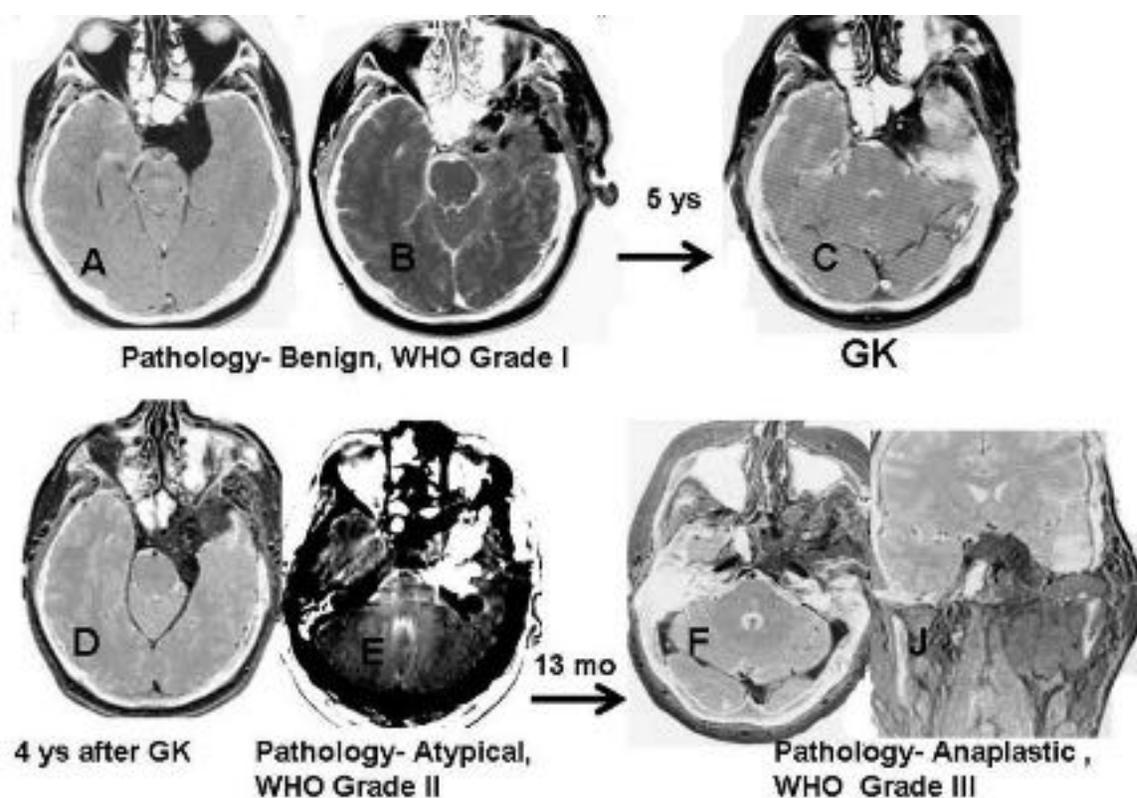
A case of meningioma progression to malignancy with a history of radiation administered to residual tumor. (A) Magnetic resonance imaging (MRI) of the original tumor, which was a grade I benign tumor. (B) Postoperative residual tumor remaining around the cavernous carotid. (C) MRI at the time of treatment with gamma knife (GK) for residual tumor. (D) Recurrent tumor after radiosurgery. (E) Postoperative MRI of surgical resection of a now aggressive grade II meningioma. (F) Axial and coronal MRI of a massive recurrence with now grade III anaplastic meningioma.
